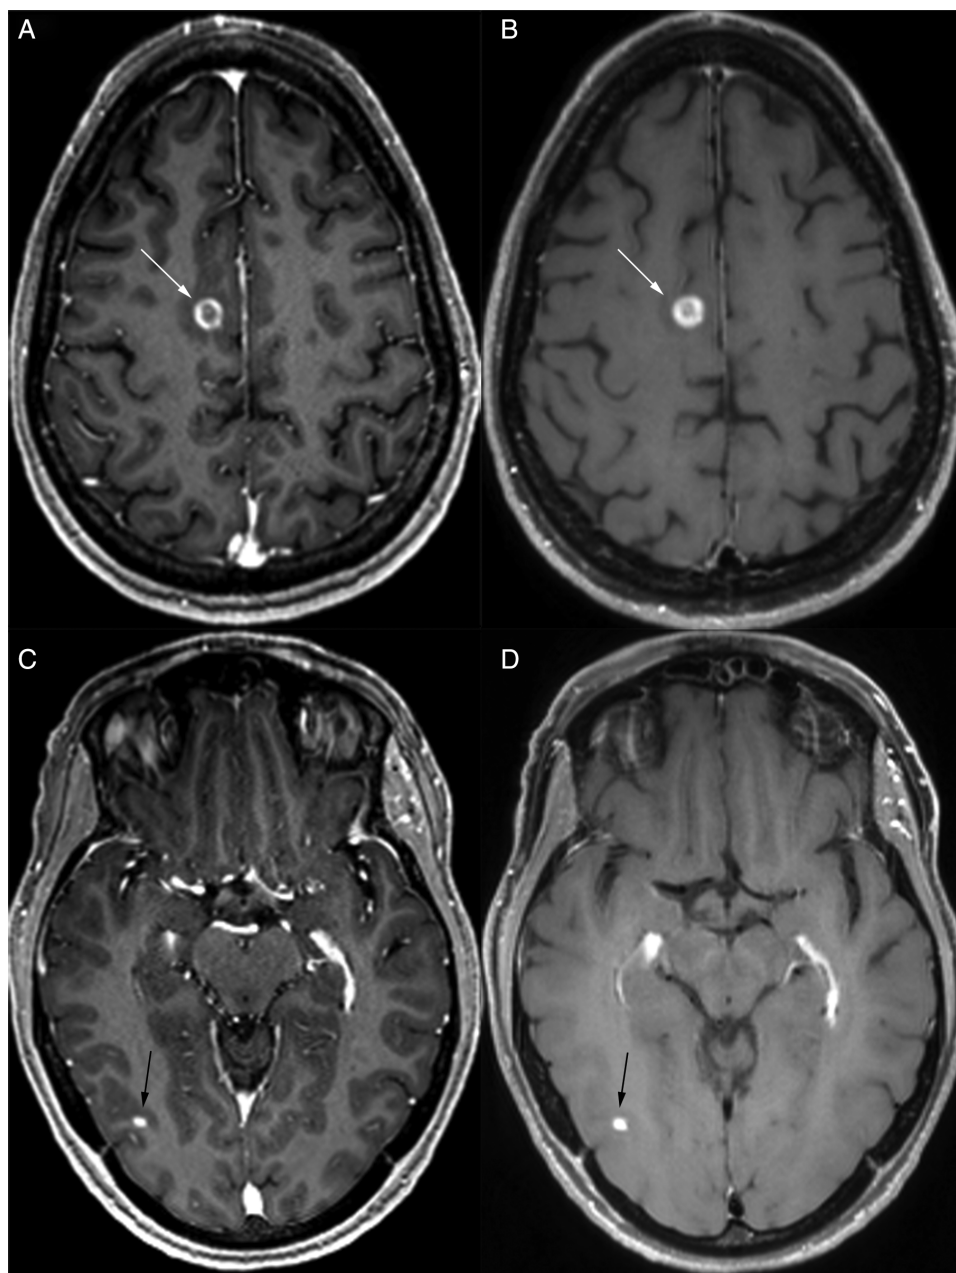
Comparison of 3D IR-GRE (A, C) and 3D TSE (B, D) T1-weighted imaging in a patient with metastatic lung carcinoma to the brain. Larger lesions (eg, right posterior frontal, white arrows, A and B) are well visualized with both techniques. Smaller lesions (eg, right posterior temporal, black arrows, C and D) may be better visualized with 3D TSE T1-weighted imaging due to more native vascular signal suppression and higher contrast:noise ratio relative to underlying brain.
